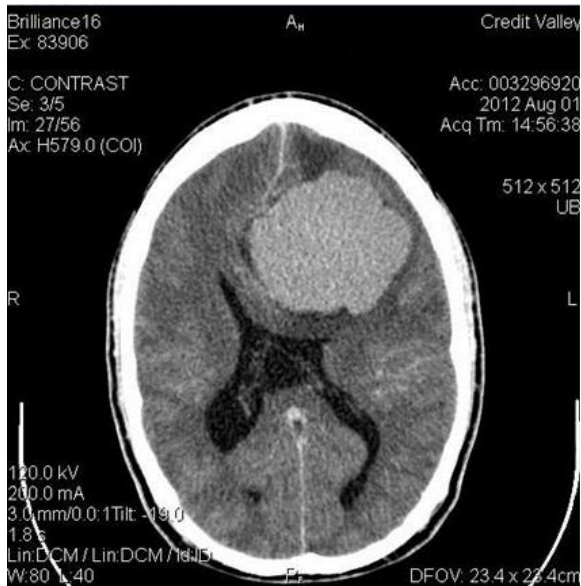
CT SCAN, CLEARLY SHOWING A TUMOUR ABOUT THE SIZE OF A LEMON
